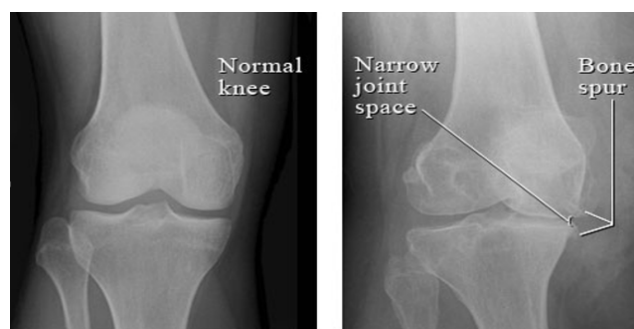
Showing x-ray of normal knee joint and knee joint osteoarthritis
